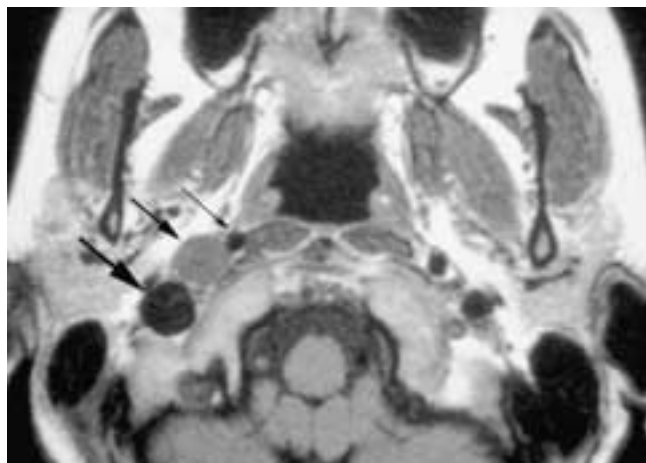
Axial T1-weighted MR image shows a mass (*medium arrow*) separating the internal carotid artery (*small arrow*) and the internal jugular vein (*large arrow*). Although the fascia forming the carotid sheath cannot be seen on imaging, its presence is noted by the fact that it restrains the vessels from simply sliding away from the schwannoma and thus allows the mass to separate them.
